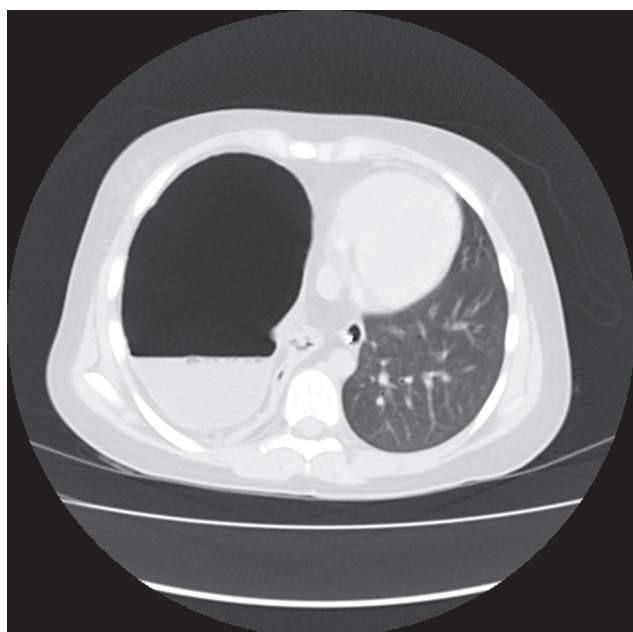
Preoperative chest CT scan
